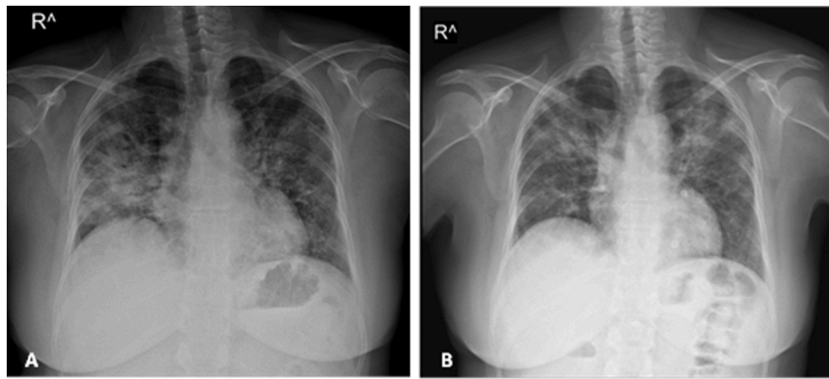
Chest X-ray at days 1 and 3.
